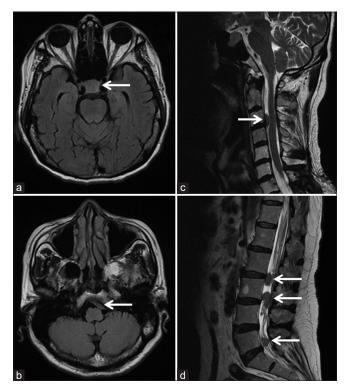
(a and b) Axial T2-weighted fluid-attenuated inversion recovery sequence images of the pituitary tumor and extradural lesion at the left prepontine cistern. (c and d) The T2-weighted fast-relaxation fast-spin echo sequence sagittal images of the extradural and intradural extramedullary drop metastases respectively
